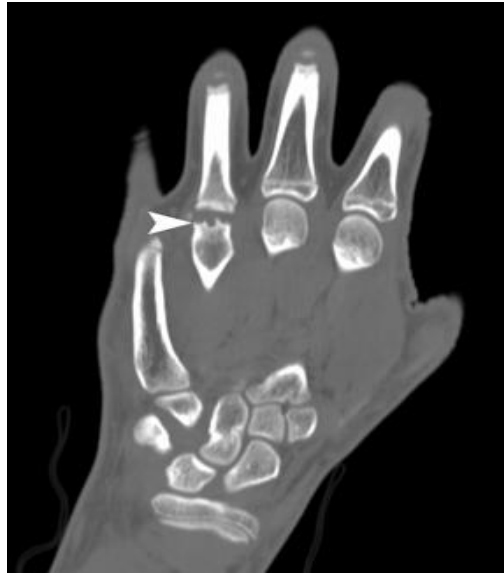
CT scan of the hand.
